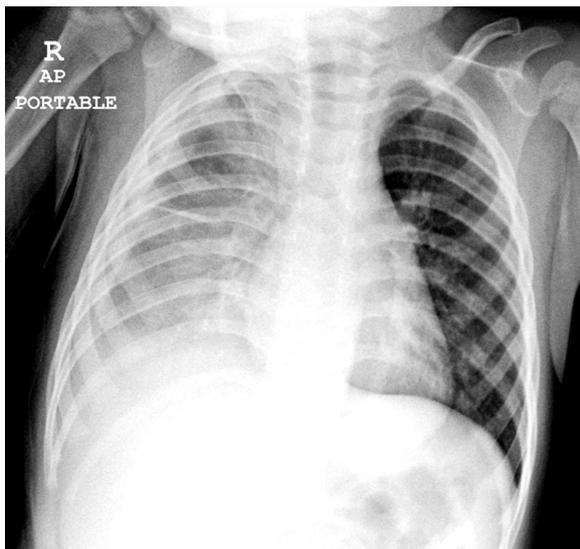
Chest X-ray on admission showing a right pleural effusion.
